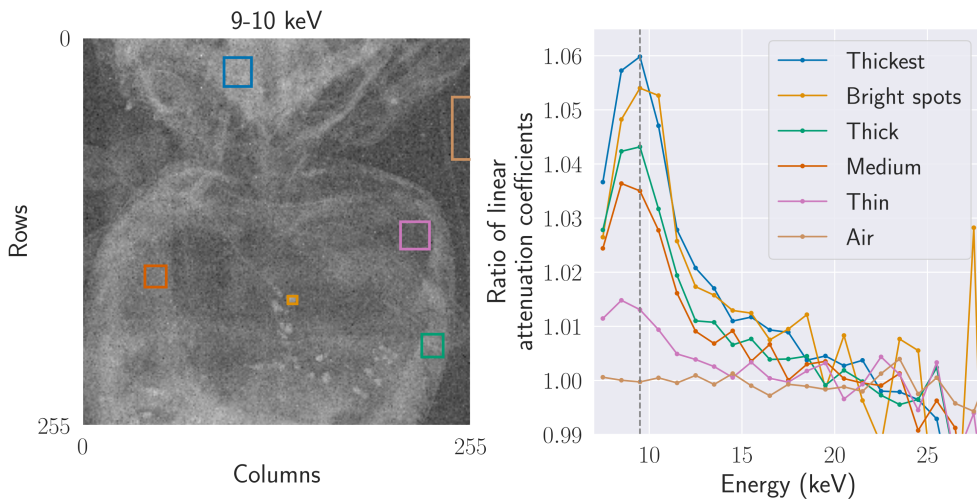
The relative linear attenuation coefficients over energy of a bee's thorax and abdomen with a corresponding labelled image at 9.0–10.0 keV as indicated by the vertical dashed line. The x-ray tube voltage used in this measurement was 30 kVp with a Si detector. The coloured squares show the manually selected region of interest where the median of that part of the image over energy was used to generate the line plots.
